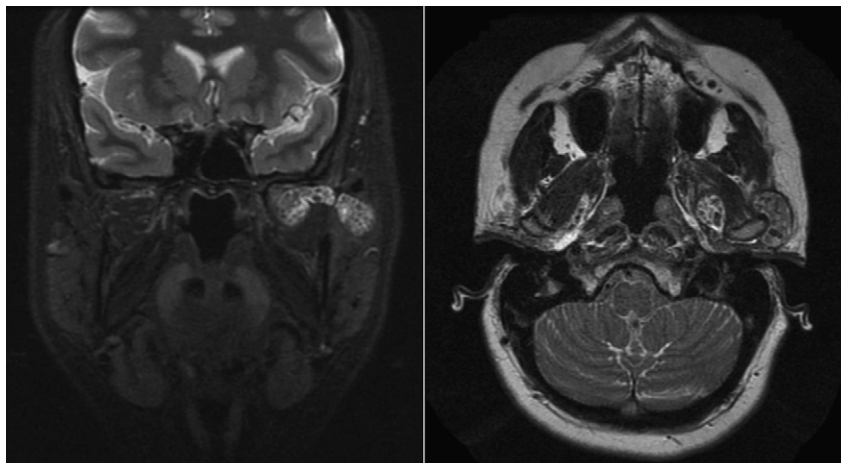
Preoperative coronal and axial sections of MRI. Left TMJ: intra-articular bodies and thickened synovium. Right TMJ: joint effusion and scarce calcifications in the medial joint space.
